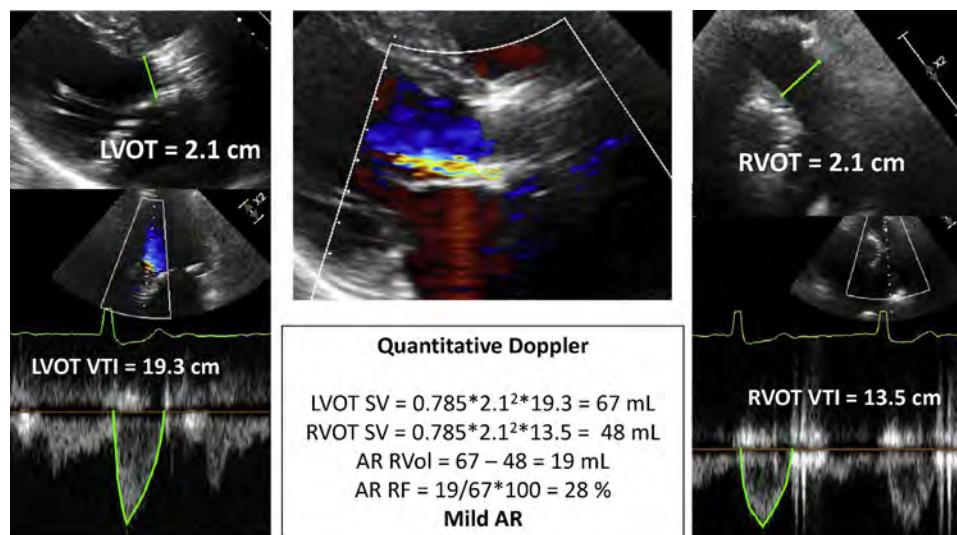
Quantitative Doppler for assessing regurgitant volume (RVol) and regurgitant fraction (RF) in a patient with AR after TAVR. Stroke volume (SV) is calculated at the LVOT and RVOT in this patient with mitral annular calcification. Flow quantitation complements other assessments of AR severity.
